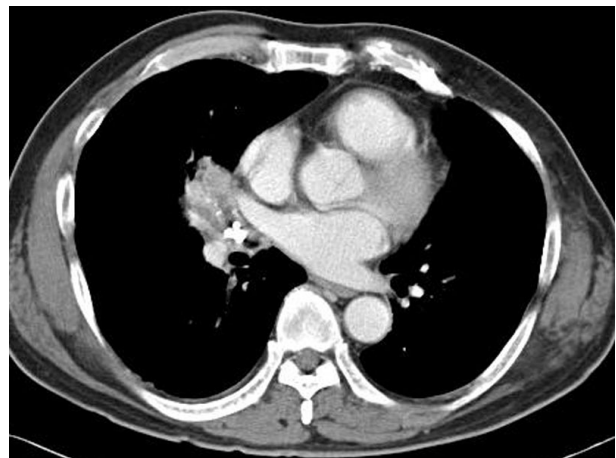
Chest CT shows a calcified stone in the bronchus and atelectasis in the right middle lobe.
